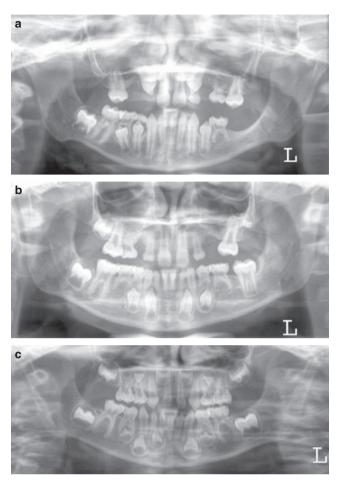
Panorex radiographs. (a) V.H.J. (b) V.H.A. (c) V.H.L.
